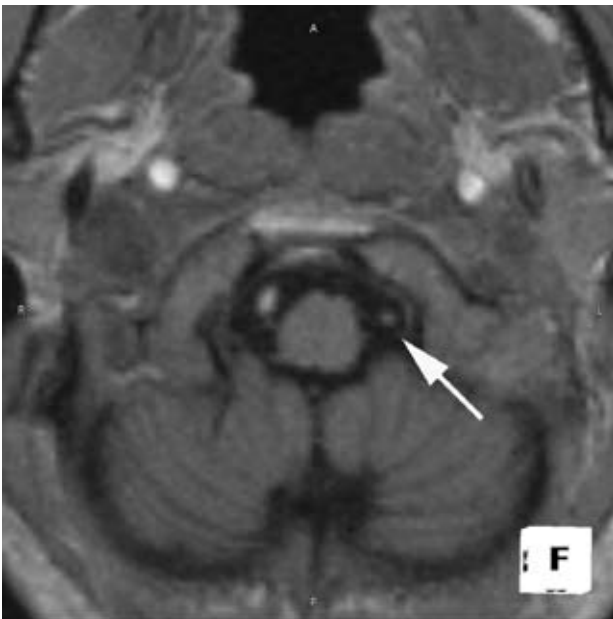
Cranial MRI showing diminutive signal from the left vertebral artery
